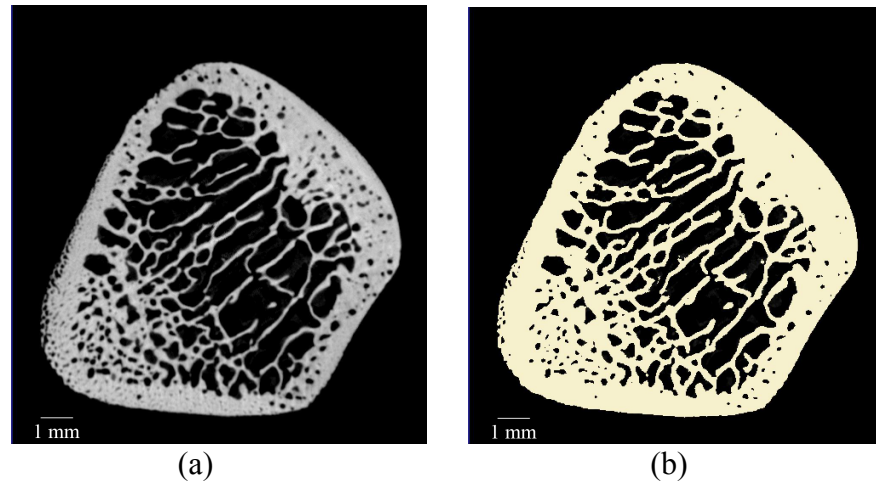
Transverse cross-section through mature rib section (a) X-ray CT image data (b) applied segmentation of the model mask
